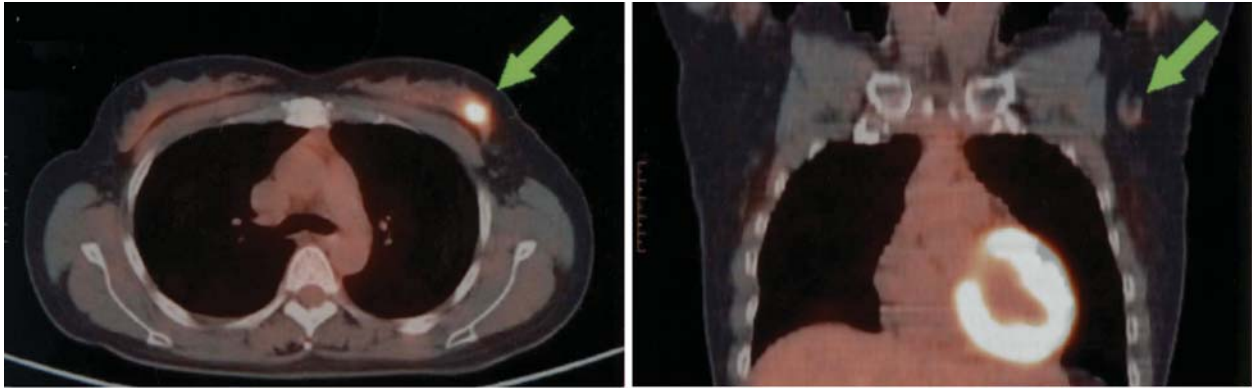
On positron emission tomography/computed tomography examination,  $^{18}\text{F}$ -fluorodeoxy glucose (FDG) was highly accumulated in the lesion in the left breast (maximum standard uptake value=6.8), and a large left axillary lymph node was demonstrated, but the accumulation of FDG to the latter was not significant, and no distant metastases were seen.
